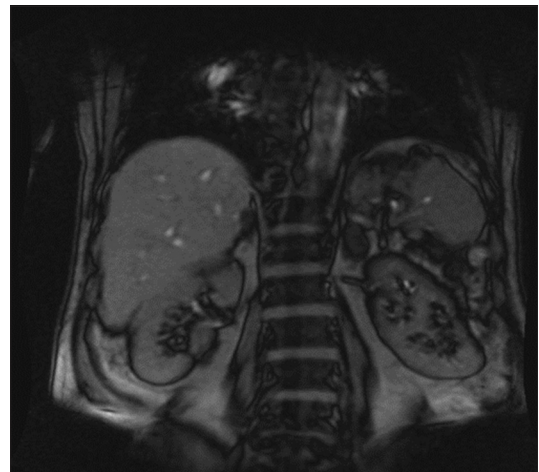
Magnetic resonance imaging confirmed the evidence of 4 cm × 5 cm × 2 cm left adrenal suspicious solid mass
